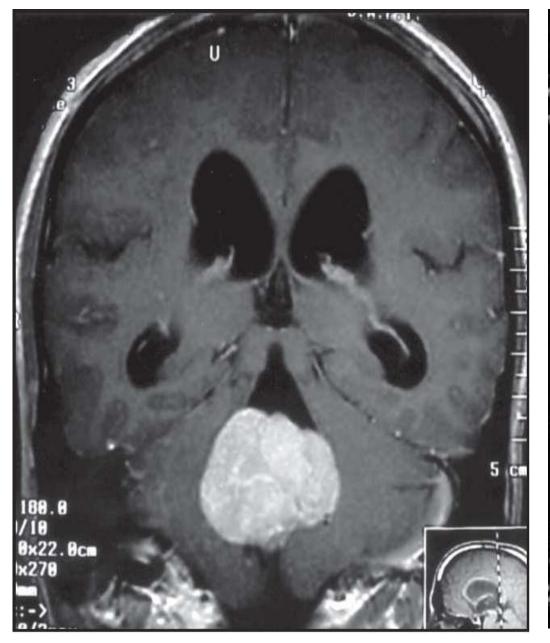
Coronal T1 weighted MRI after contrast injection revealing
